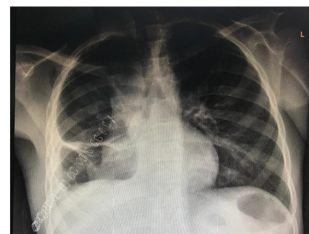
Chest radiograph on postoperative day seven showing post thoracotomy and right lower lobectomy changes on the right. There is persistent volume loss and elevation of the right hemidiaphragm with atelectasis of the right mid and lower lung field due to pulmonary fibrosis. Right mediastinal shift is present due to compensatory hyperinflation of the left lung. Blunting of the right costophrenic angle is seen due to pleural scarring and likely small pleural effusion.
